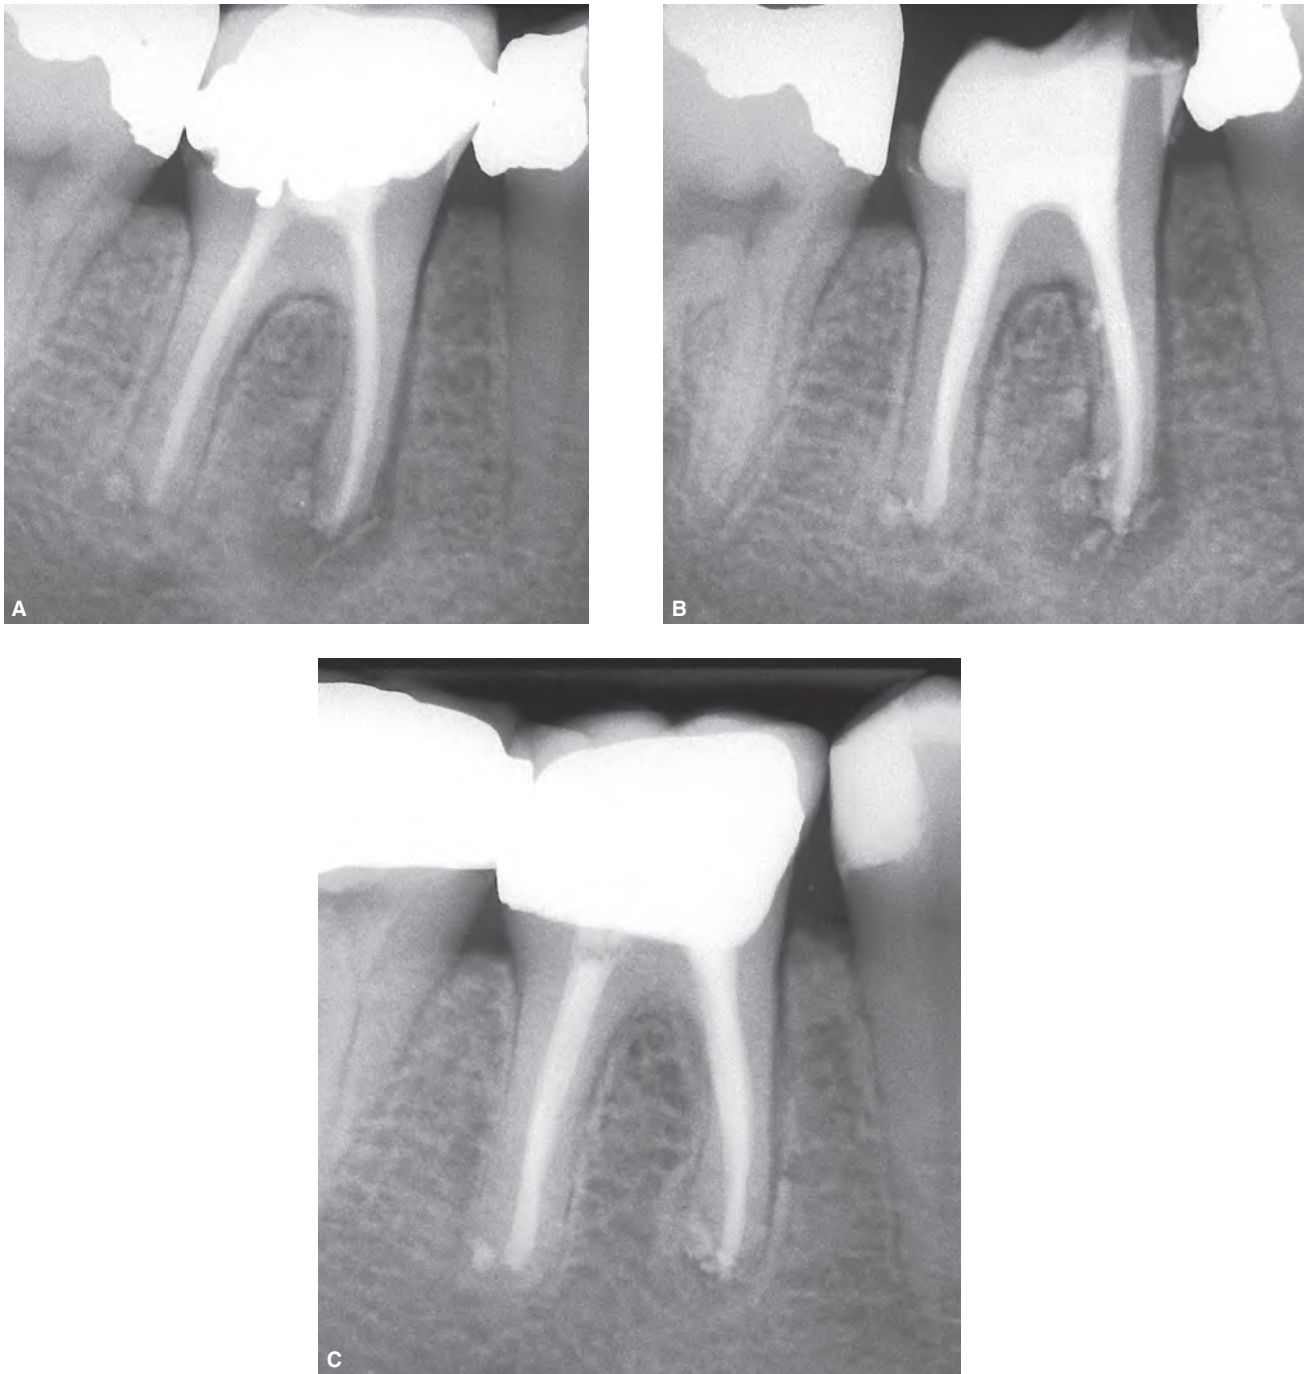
A. Preoperative radiograph of the mandibular right first molar improperly treated. A radiolucency is associated with the apex of the mesial root. Filling material (sealer and/or gutta-percha) is present in the lesion. B. Postoperative radiograph. During retreatment two missed root canals from the prior treatment were found. The distolingual and the middle mesial canals had independent foramina. C. Seven-year recall radiograph showing that the apical lesion has resolved and the excess material disappeared. Again, the apical lesion was most probably caused by an infected root canal system and NOT by a foreign body reaction to the overextended gutta-percha.
